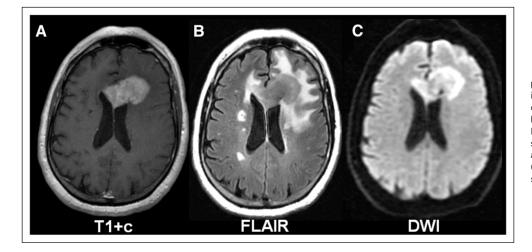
Characteristic primary CNS lymphoma imaging pattern on magnetic resonance imaging. (A) T1 sequence with gadolinium contrast (T1+c) demonstrates a single, frontal, homogenously enhancing brain lesion. (B) Fluid-attenuated inversion recovery (FLAIR) sequence visualizes a comparatively small area of edema surrounding the mass lesion. (C) Diffusion-weighted imaging (DWI) demonstrates restricted diffusion within the tumor.
